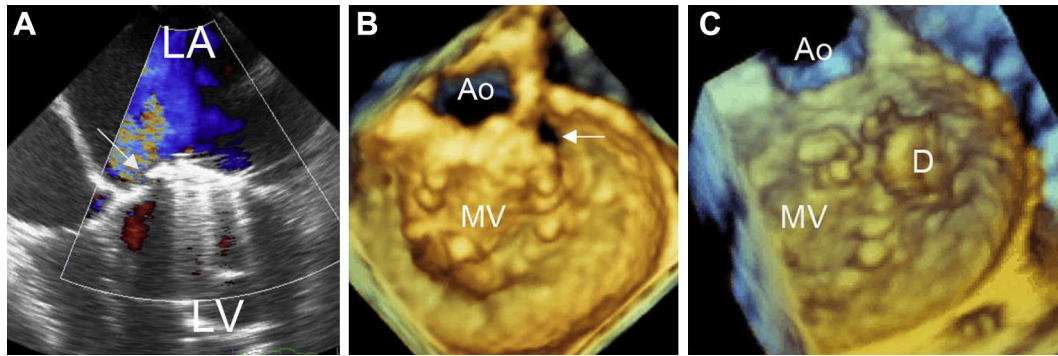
Transapical closure of mitral paravalvular leak. (A) Apical four chamber view of two-dimensional (2D) transesophageal echocardiography (TEE) shows a paravalvular leak (arrow); (B) 3D TEE image of the mitral annulus and mechanical prosthesis en face from the left atrium in diastole. The paravalvular defect is located along the anteromedial border of the prosthesis ring at 3 o'clock (arrow); (C) 3D TEE image of the mitral annulus and mechanical prosthesis en face from the left atrium after introduction of a 10-mm Amplatzer muscular occluder device seated on the defect. Ao = aorta; D = Amplatzer occluder device; LA = left atrium; LV = left ventricle; MV = mitral valve.
